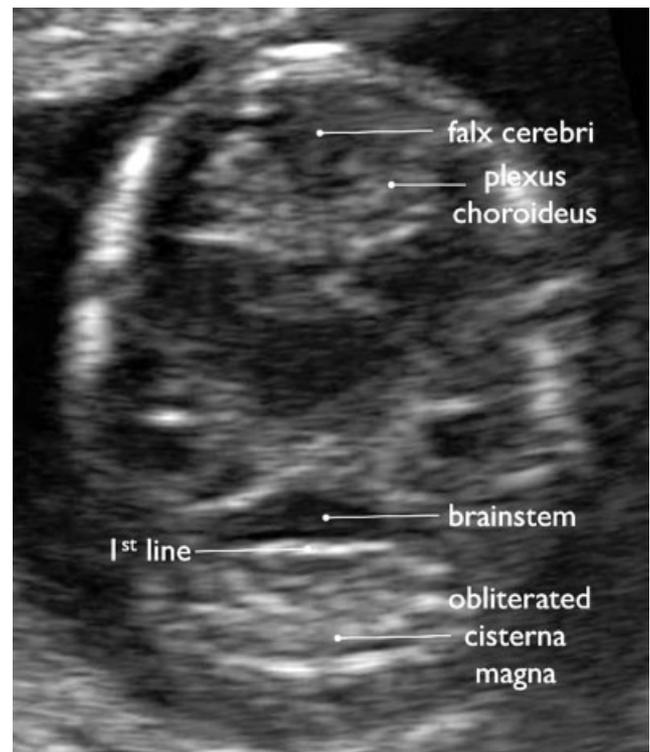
Transabdominal ultrasound image showing posterior fossa in a 13 + 4-week fetus with spina bifida. Only the first line (posterior border of the brainstem (1st line)) is visible.
